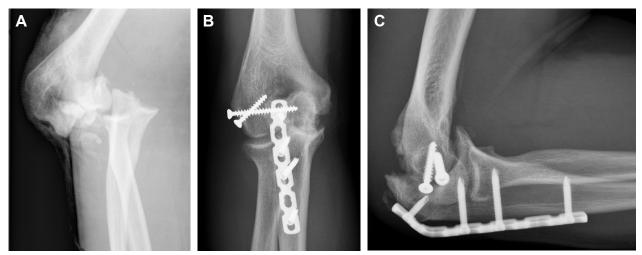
(A) A 33-year-old man sustained a Gustilo type IIIA, Mayo type IIIB olecranon fracture. (B) and (C) The fracture was stabilized with a locked plate and X-ray showed union without malalignment at the 12-month follow-up visit.
